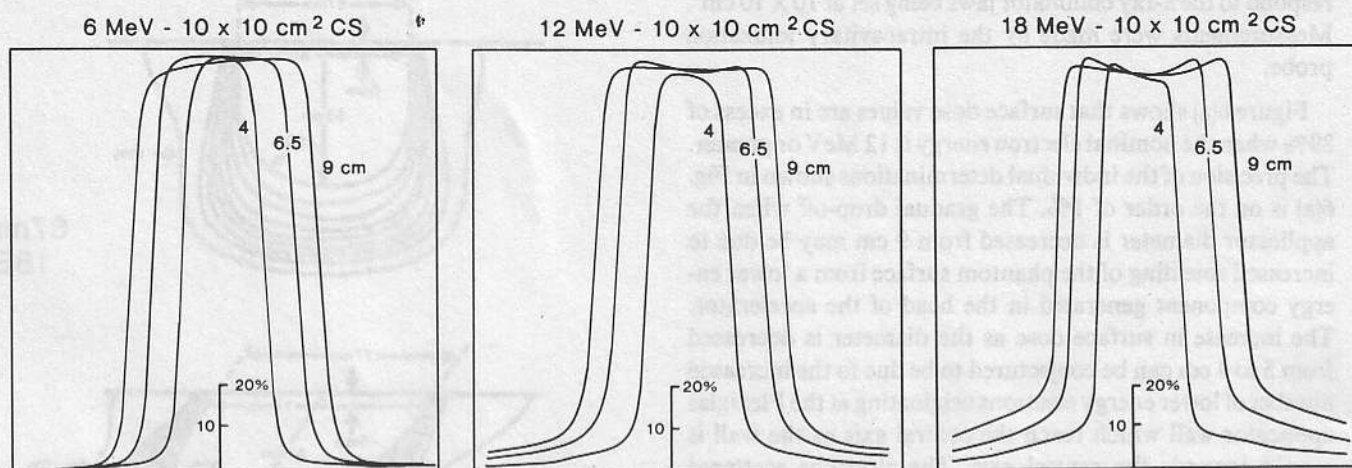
Cross-field plots of absorbed dose for perpendicular end circular applicators for diameters of 4, 6.5, and 9 cm. Data are at depth of d_{\max} (1 cm for 6 MeV, 2 cm for 12 and 18 MeV) and for an x-ray collimator jaw setting of $10 \times 10 \text{ cm}^2$.
